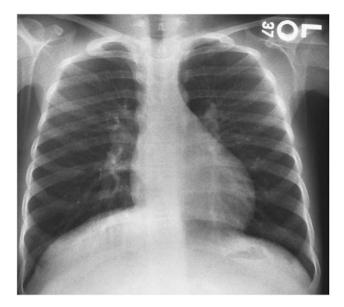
Roentgenogram of the chest of C.T., a 10-yearold girl with α_1 -AT deficiency. There were no pulmonary symptoms, but bronchial markings were increased as linear densities, there was hilar prominence, and there was evidence of hyperinflation.
